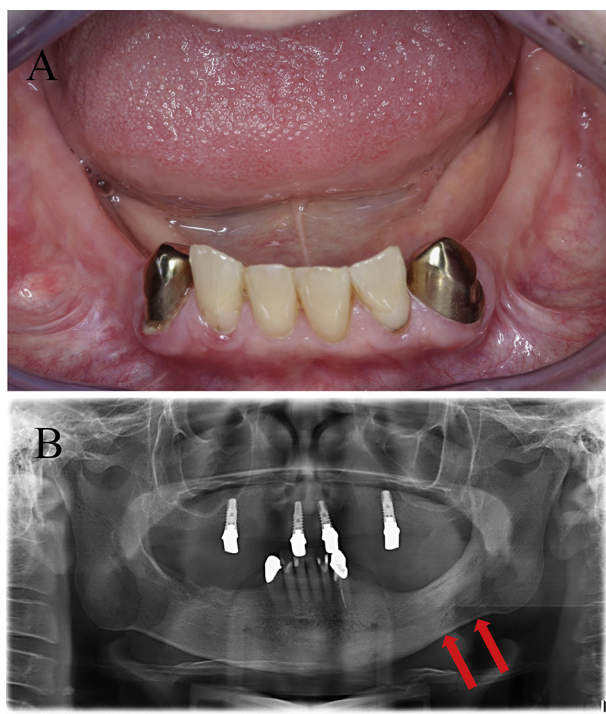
(A) Clinical situation before treatment: normal mucosal tissue in the left mandible (region 33 to 37) with no signs of infection or fistula formation. (B) A panoramic radiograph showing high grade of sclerosis in the left mandibular corpus.
